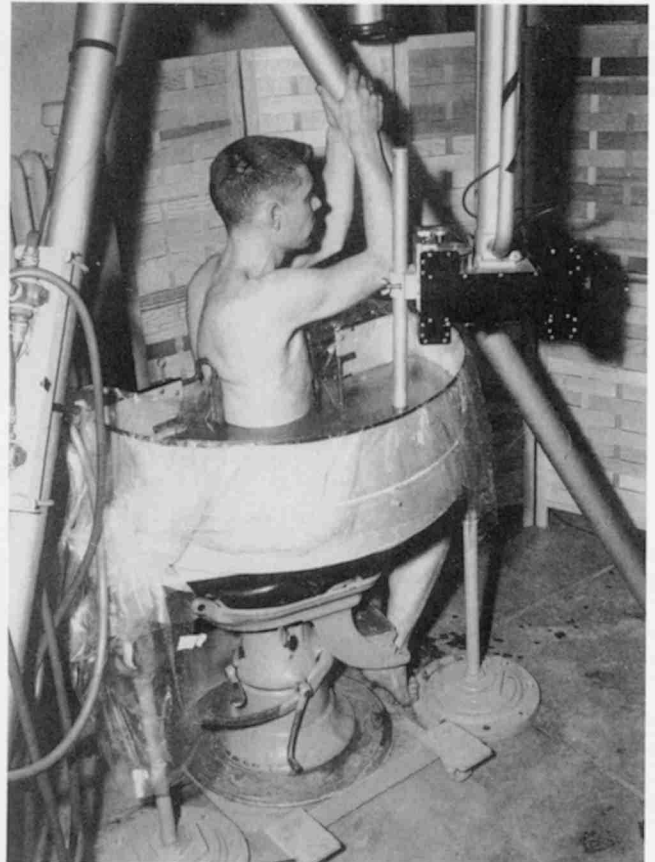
Howry team's "pan scanner," developed about 1957–1958. Patient sat in a modified dental chair and was strapped against plastic window of a semicircular pan filled with a saline solution. Transducer rotated through the solution in a semicircular arc around the patient. A great many clinical scans were performed with this scanner, which was more appropriate for use on patients than earlier total immersion scanners were. (Reprinted with permission from *Medical Diagnostic Ultrasound: A Retrospective on Its 40th Anniversary*.)
